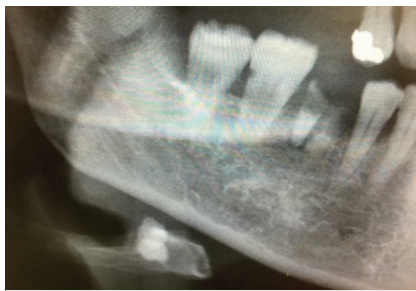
Orthopantomograph revealing three radiopaque lesions below the right lower border of the mandible
